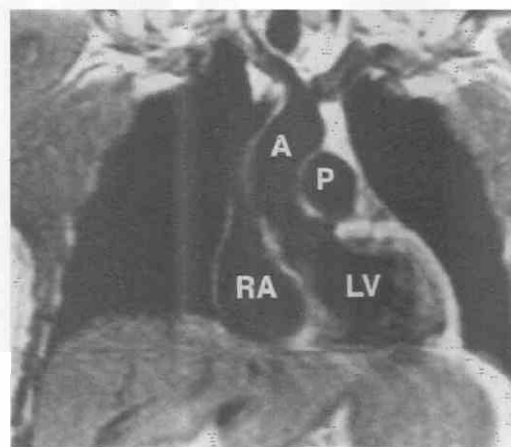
Anterior coronal MR image. A, ascending aorta; LV, left ventricle; P, main pulmonary artery; RA, right atrium.
